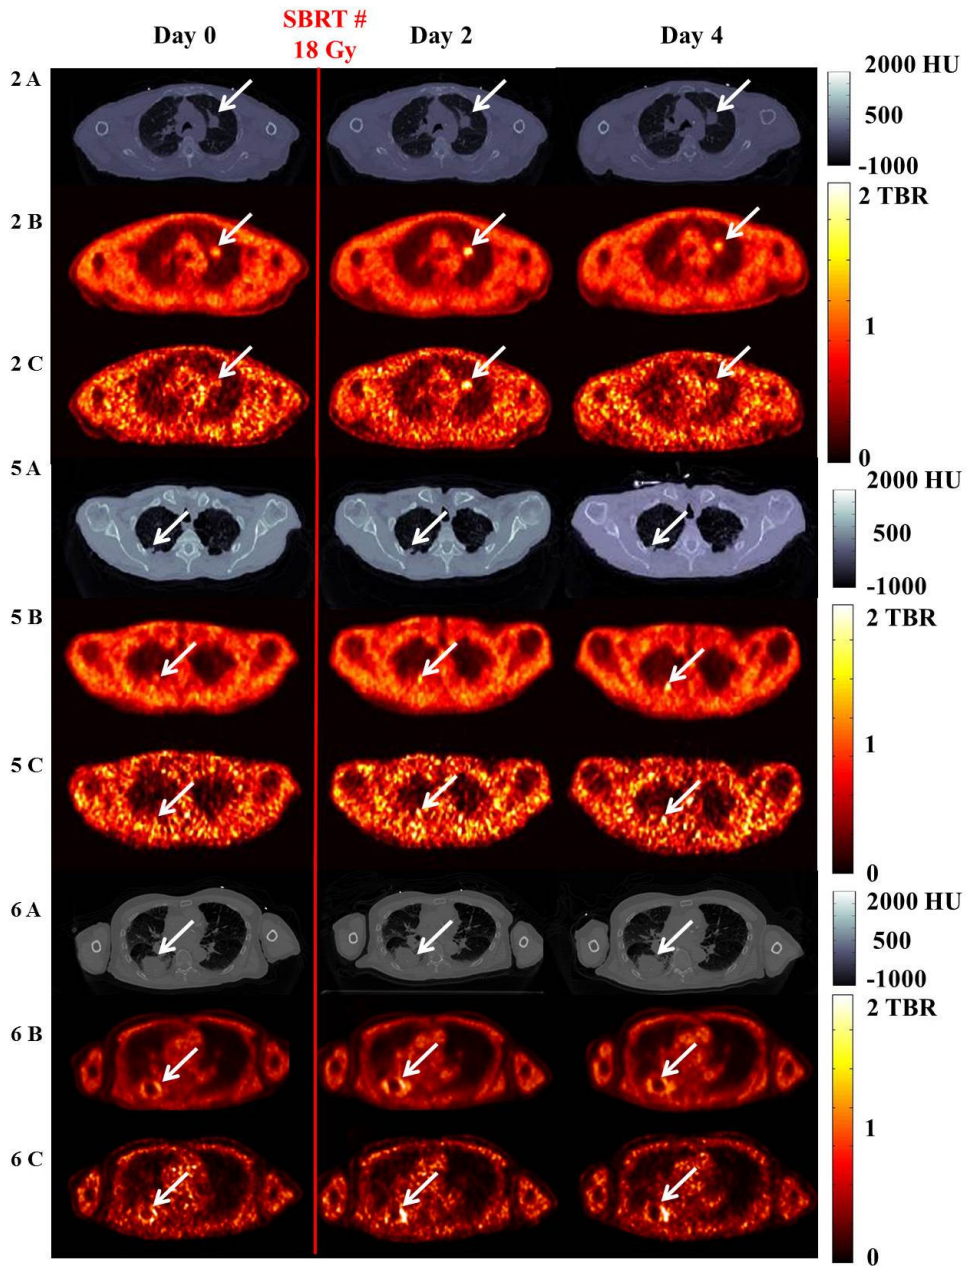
Representative axial images for patients with baseline tumor hypoxia (patient 2 (2A-C), patient 5 (5A-C), and patient 6 (6A-C)) show variation in the tumor HV (day 0 to 4). Red vertical line indicates SBRT fraction delivery (18 or 10 Gy) immediately after day 0 imaging. Rows (A) show CT images (scale bar in Hounsfield Units [HU]). Rows (B) and (C) show ungated and respiratory-corrected PET images. Arrows indicate the tumor or hypoxia. Scale bar in TBR (no units).
